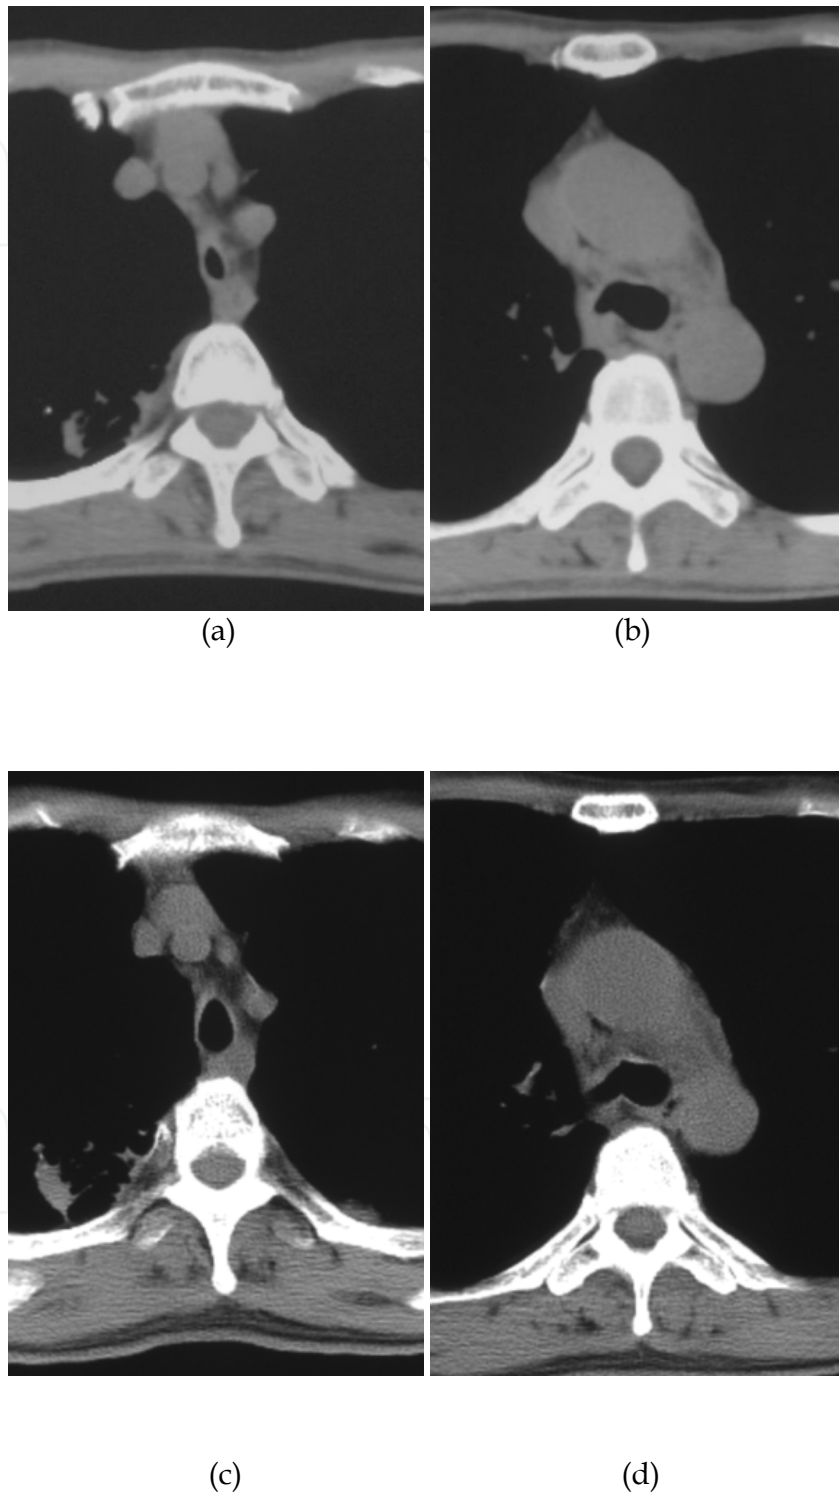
Chest CT of patient 7 shows severe stenosis of the trachea (a) and the right main bronchus (b) before BBD. However, BBD brings a significant increase in the diameter of the trachea (c) and the right main bronchus (d).
